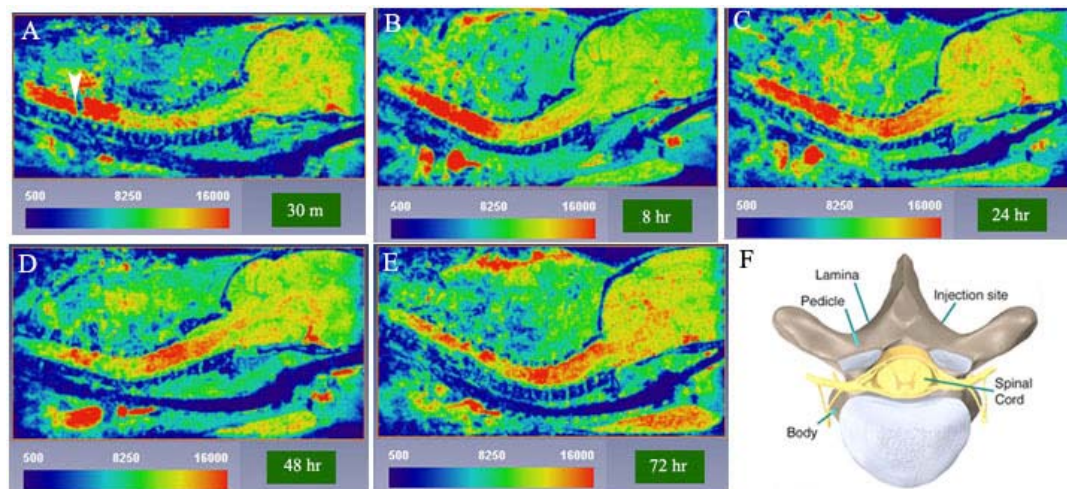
Time-lapse MRI after direct SC injection of Mn^{++} (A-E); at 30 min, intensity enhancement is seen near the injection site (arrowhead). At a later time points, 8, 24, 48 and 72 hr, detectible increases in MR intensity occur gradually over time along the SC. F, spinal cord anatomy.
